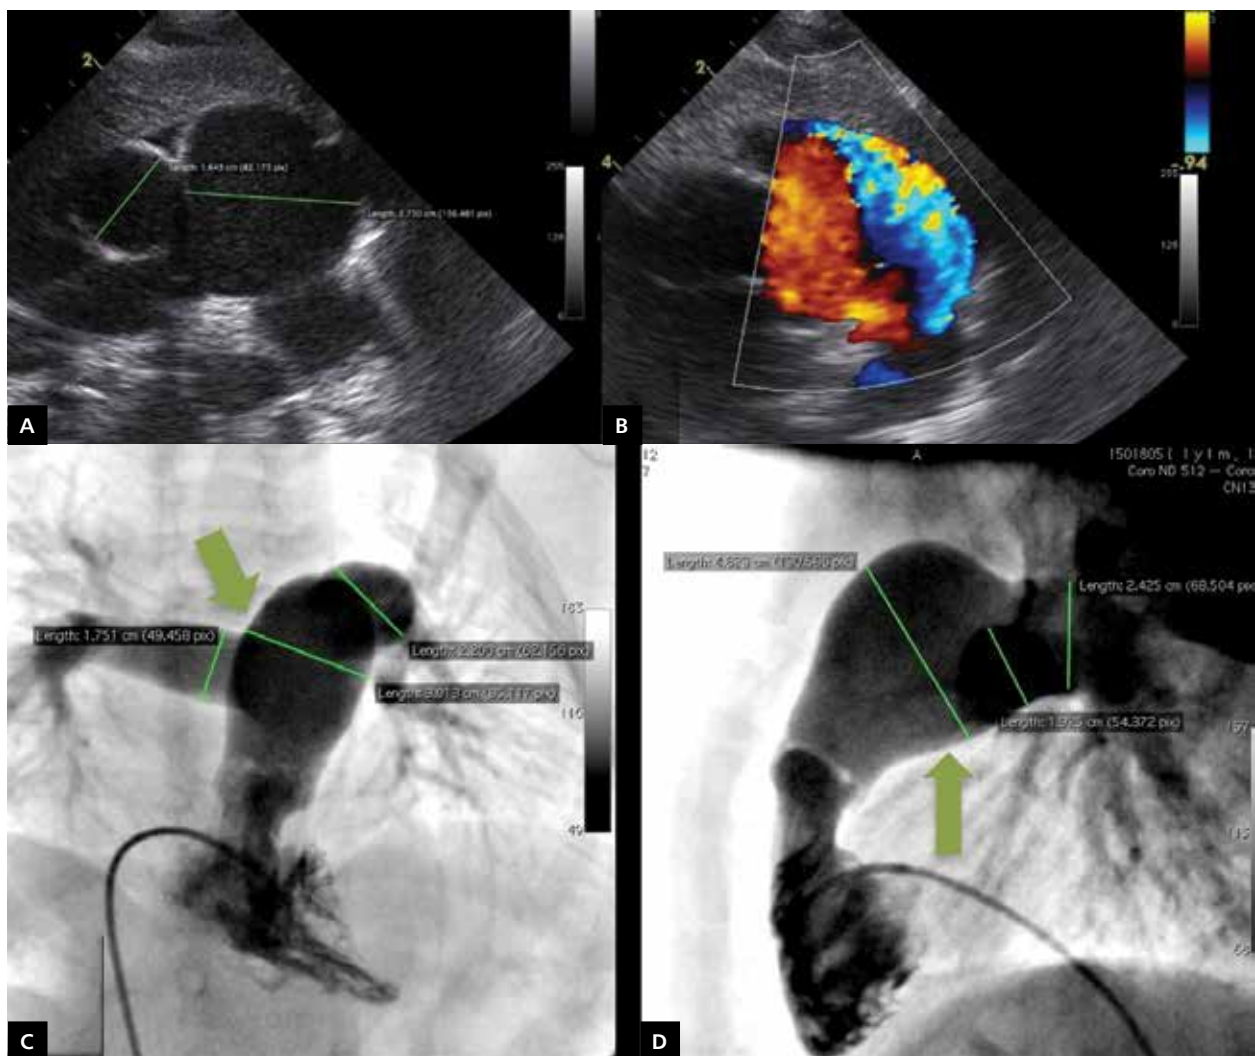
13 m.o. child with pulmonary stenosis and pulmonary artery aneurysm (PAA): two-dimensional transthoracic echocardiography (TTE) short axis view showing the aneurysm of main pulmonary artery (2.7 cm compared to aortic diameter of 1.6 cm) and dilated pulmonary branches — left to a greater extent (A); colour Doppler study showing flow separation and secondary flow resulting in vortex flow pattern (B). Same patient: utilisation of angiography to reveal asymmetric nature of PAA; the frontal view underestimates the dilatation as the lateral diameter (arrow) is 3.0 cm (C) compared to the maximum dimension (arrow) of 4.6 cm as seen on the lateral view showing that the bulging is mainly towards the front and top (D). As seen also the standard TTE view, despite good echocardiographic window, grossly underestimates the true degree of aneurysmal dilatation due to its geometry
